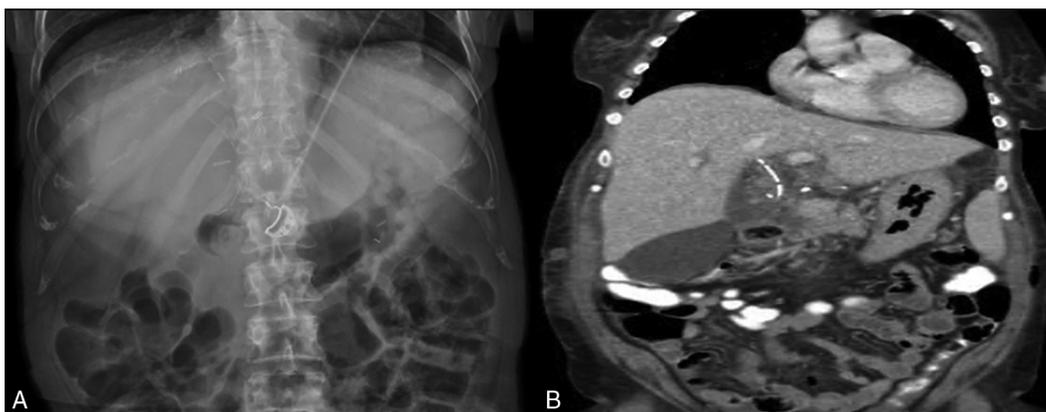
(A) Abdominal x-ray revealing biliary stent in situ with no free air noted. (B) Computed tomography showing proximal migration of biliary stent into donor bile duct with no upstream ductal dilation.
